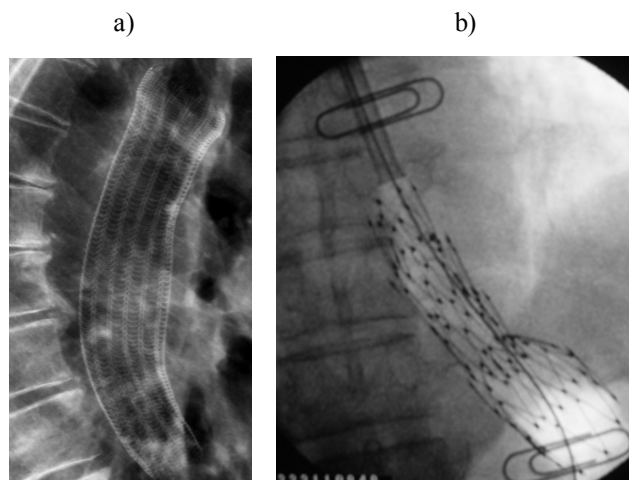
a) X-ray view of the implanted esophageal stent applied to treat the cancer obstruction by making the "by-pass" bridging, b) X-ray control of successful application of the state-of-the-art self-expanding esophageal anti-reflux stent (two paper clips were placed only on the patient skin surface to mark an area of the neoplastic infiltration)
